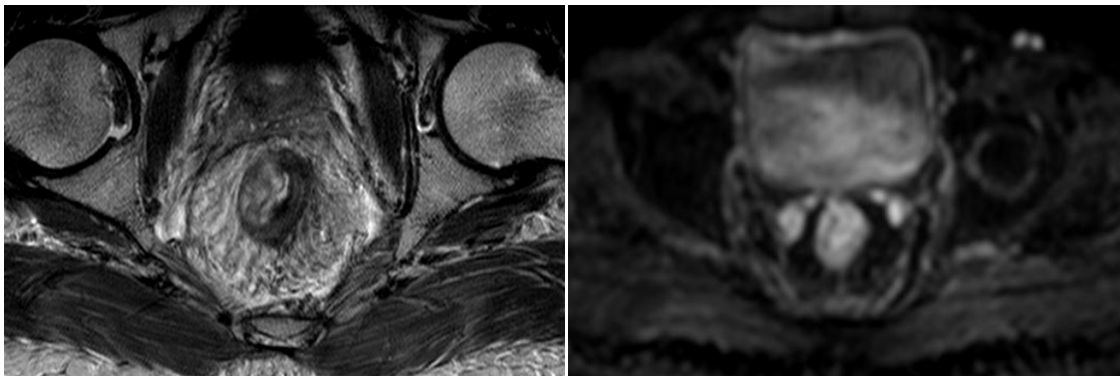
c and d: Post CRT images showing complete response, seen as fibrosis on T2w imaging and absence or restricted diffusion on DWI
